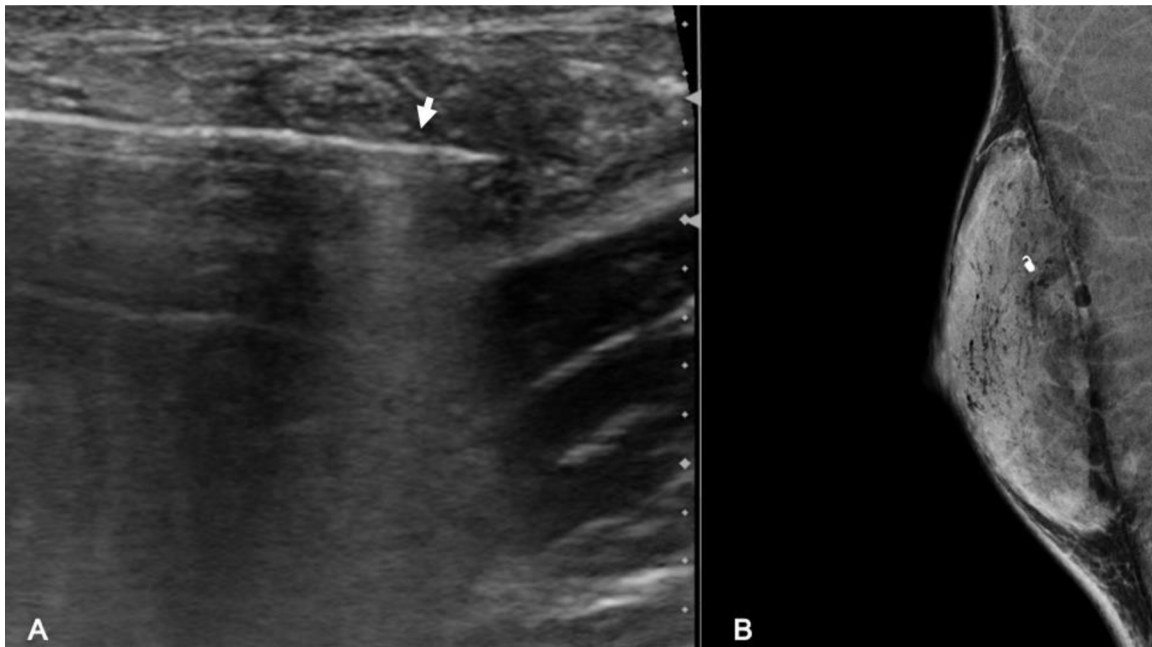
Biopsy: (A) Ultrasound-guided biopsy with a 16-gauge Bard automated core biopsy needle (white arrow); and (B) postclip mammogram in the lateromedial projection showing a postbiopsy coil clip.
